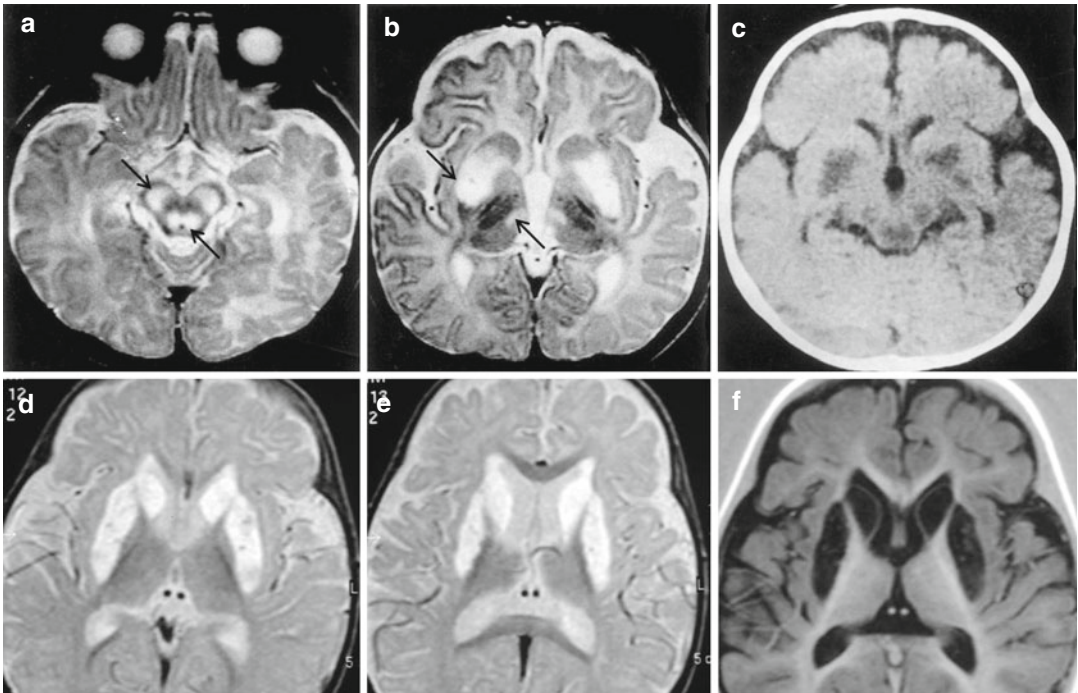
Leigh syndrome. Two different cases. *Top*, a baby of 5 months; *bottom*, a child of 3 years. *Top*, axial T2-weighted images, (a, b), and axial CT, (c), demonstrate marked hyperintensities and hypodensity in cerebral peduncles, tegmen pons, bilateral putamen, and medial
